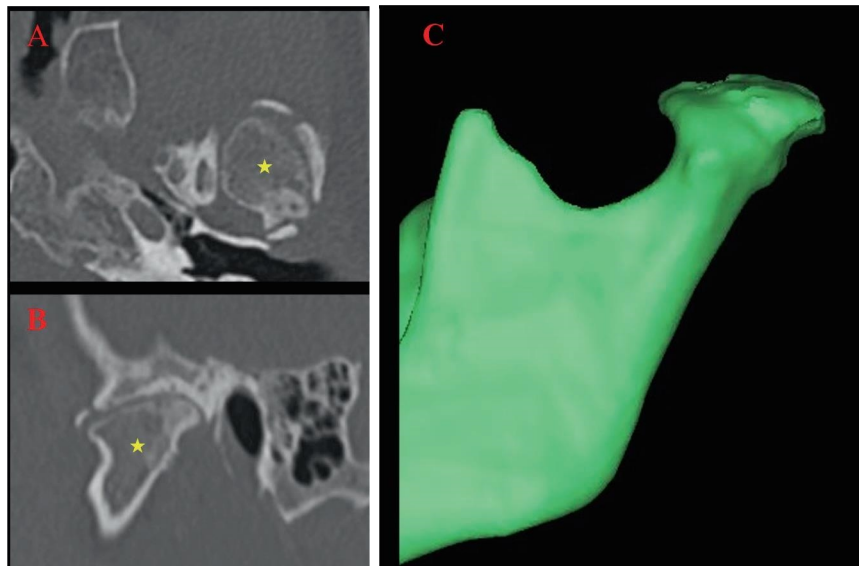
CT images: (A) Axial CT; ★, condyle. (B) Sagittal CT; ★, condyle. (C) The 3D-CT model demonstrates a well-defined, bone-like, opaque mass located around the mandibular condyle.
